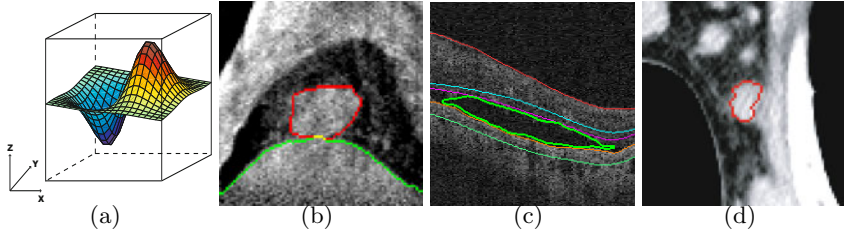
(a) The terrain-like surface intersects each (x, y) -column exactly one time. (b) Example slices of a lung tumor (red) in megavoltage cone-beam CT. The tumor is attached/adjacent to the diaphragm (green). (c) Example slices of a fluid-filled region (green) in retinal optical coherence tomography (OCT). The fluid region is surrounded by intraretinal layers. (d) Example slices of a lymph node (red) in X-ray CT data. The lymph node is connected to surrounding soft tissues.
